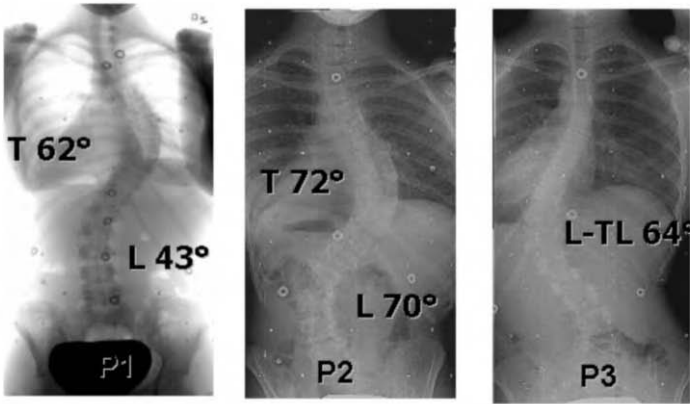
Preoperative standing postero-anterior radiographs (PA) of the three patients
